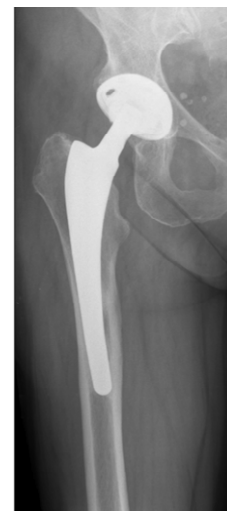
Radiograph of the revision THA.
